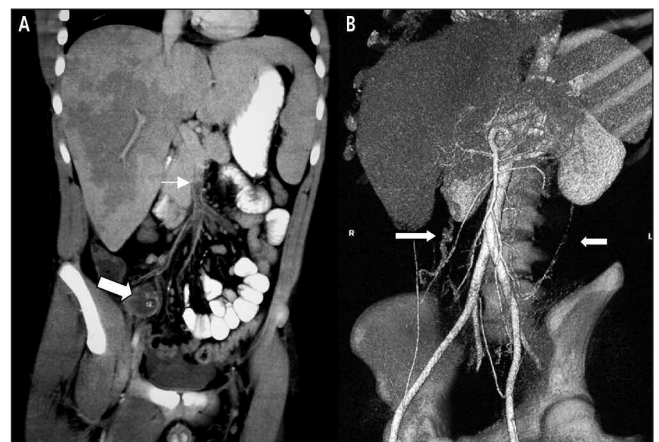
A. CT shows an inflammatory mass in the right lower abdominal quadrant (large arrow) and thrombosis of the superior mesenteric vein (small arrow). B. Vascular reconstruction showing collateral circulation through colic veins (arrows).
